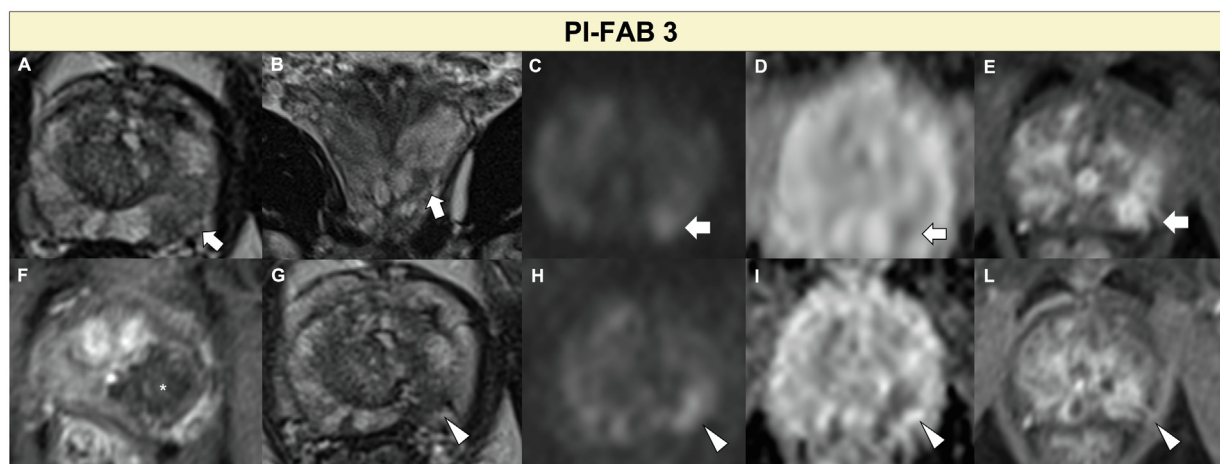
Pretreatment (A) axial and (B) coronal T2-WI, (C) high-*b*-value, (D) ADC map, and (E) DCE acquisitions show a lesion in the left peripheral zone at the midgland (arrows; Likert 5/5) treated with high-intensity focused ultrasound. (F) Early post-treatment MRI findings show the necrotic cavity (asterisk) on DCE sequences with adequate coverage. However, following a rise in PSA, MRI after 5 years shows (arrowheads) (G) a focus of low T2 signal, restricted diffusion on (H) the high-*b*-value sequence and (I) the ADC map, and (L) enhancement in the same location as the original tumour. The Prostate Imaging after Focal Ablation (PI-FAB) score is 3. ADC = apparent diffusion coefficient; DCE = dynamic contrast-enhanced imaging; DWI = diffusion-weighted imaging; MRI = magnetic resonance imaging; PSA = prostate-specific antigen; T2-WI = T2-weighted imaging.
